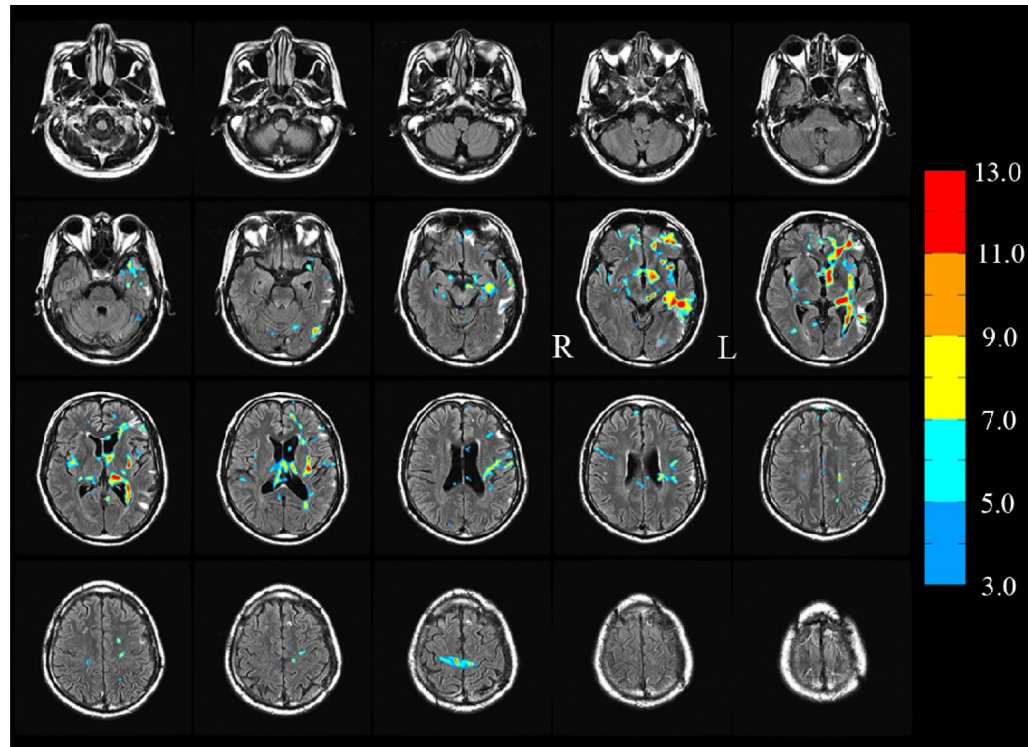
FA reduced regions corresponding to $t \geq 3.0$ (see color bar) subject 1. An extent threshold $k \geq 12$ was also used to identify clusters. Some FA-reduced identify regions overlap completely, others partially and some do not overlap with the FLAIR spots. (In this montage, the left hemisphere L appears at the right in each image).
